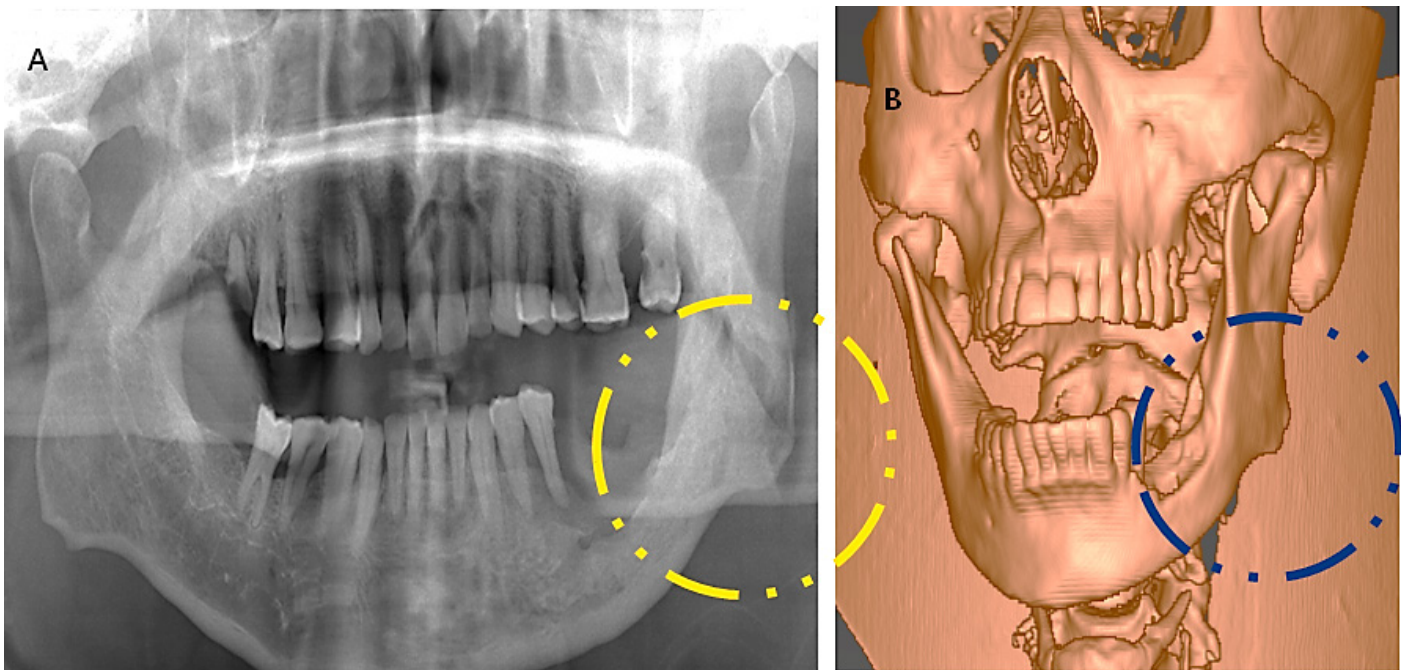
Preoperative X-ray(A) and 3D CT image(B) (yellow and blue dashed lines: tumor lesion).
